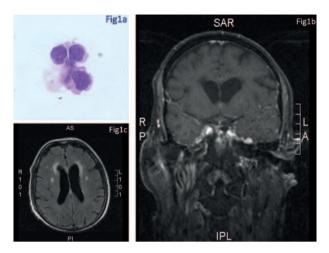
a. CSF cytology showed a few atypical large lymphocytes and monocytes; b. Brain MRI, T1 sequence with gadolinium: diffuse and nodular contrast enhancement of the meninges predominates at the skull basis, in the left posterior fossa, clivus and left temporal fossa; c. Brain MRI, FLAIR sequence: abnormal (non specific) signals are detected in the peri-ventricular white matter and in the centrum semi-ovale.
